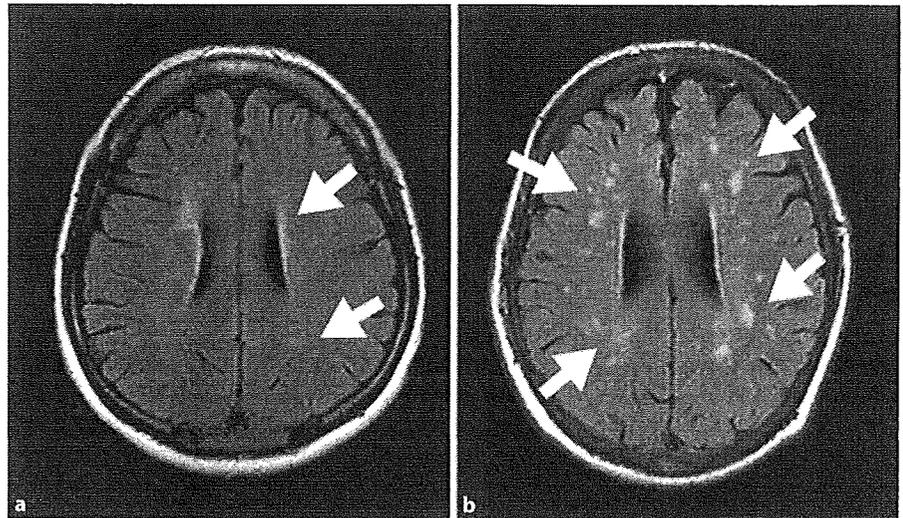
Brain MRI of cases 1 (a) and 2 (b). Arrows point to white matter lesion.
